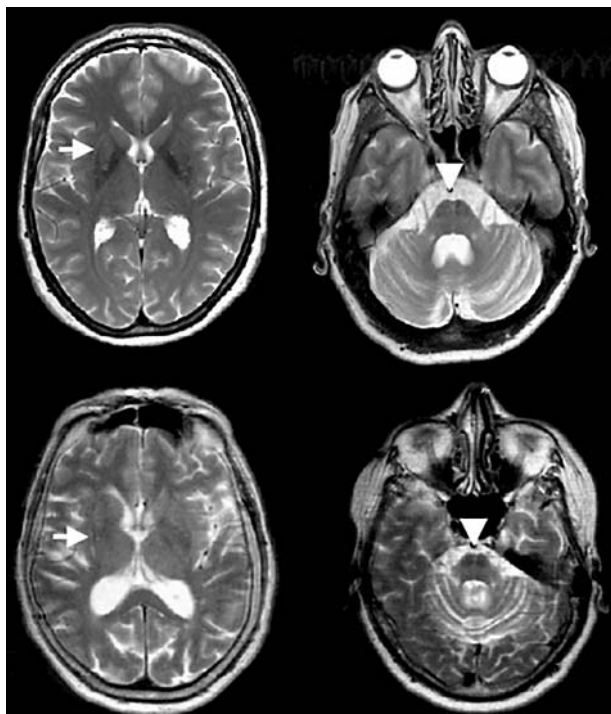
T2 weighted horizontal magnetic resonance images at the level of the basal ganglia (left) and the brain stem (right): bottom, I₁; top, II₁. Note the atrophy of the cerebellar peduncle with gliosis and the hot cross bun sign in the brain stem (arrowheads). Only moderate gliosis is present at the outer rim of the putamen (arrows).
